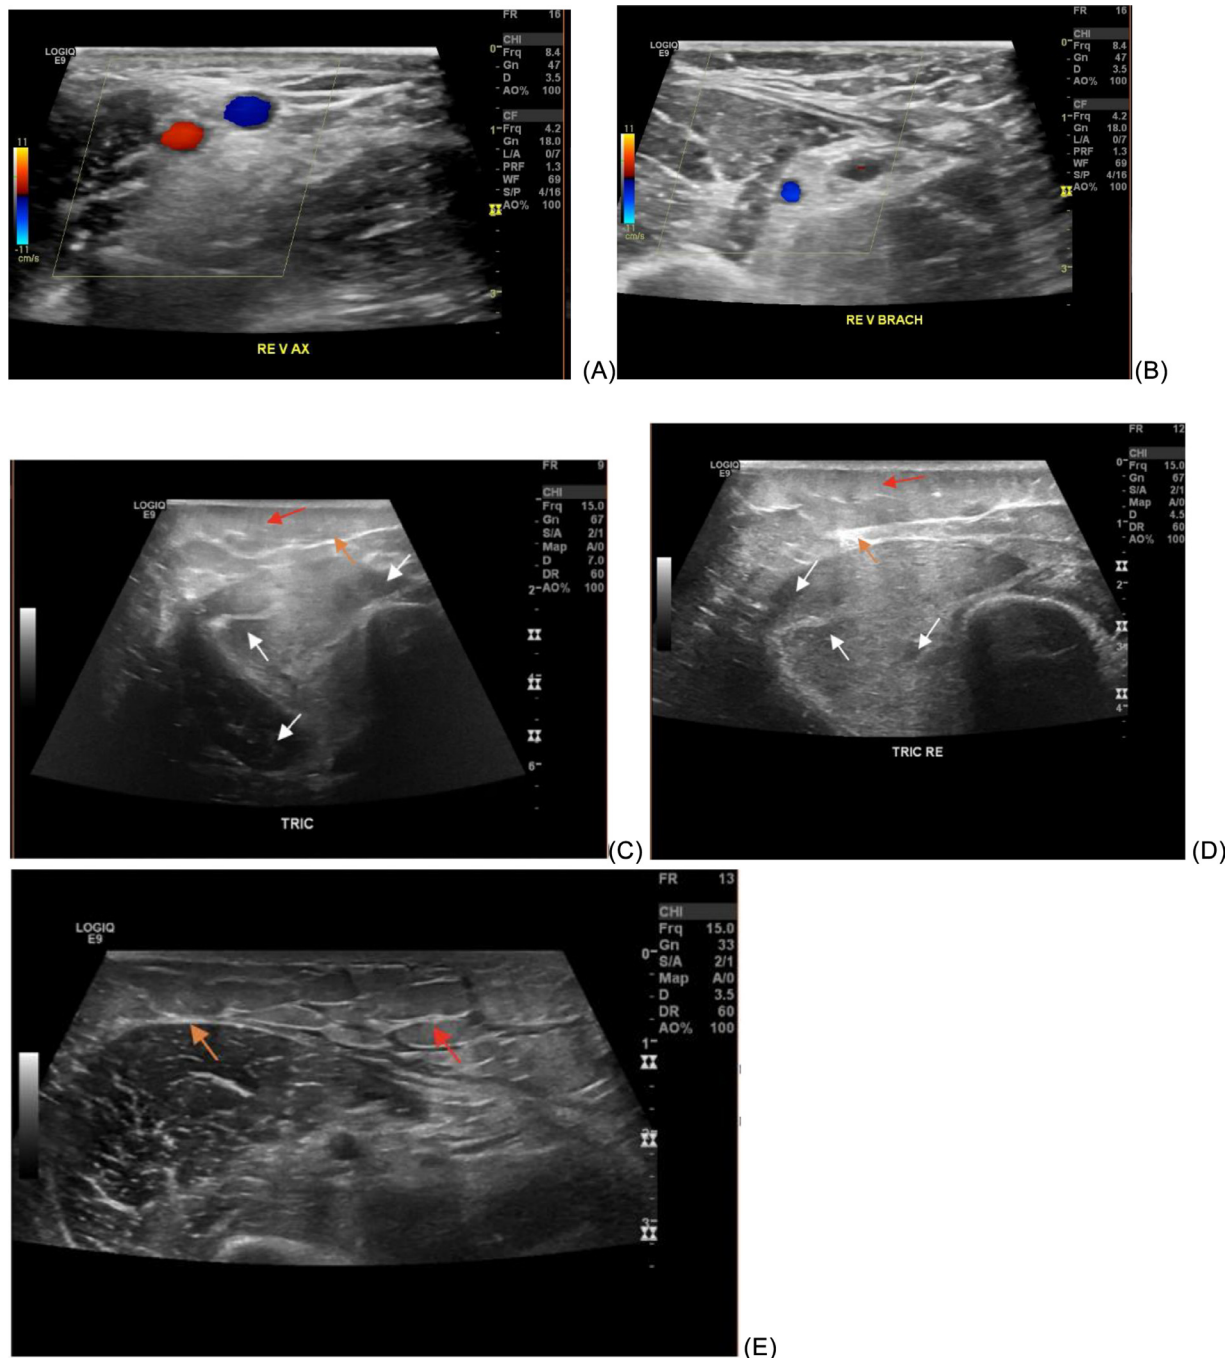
Color-doppler ultrasound images of patent right vena axillaris and vena brachiocephalica (image A and B). Ultrasound images of the triceps muscles in longitudinal section showing anechoic areas compatible with oedema (white arrows), increased muscle fascia (orange arrows) and infiltration of adjacent subcutaneous adipose tissue (red arrows) (image C, D, and E).
